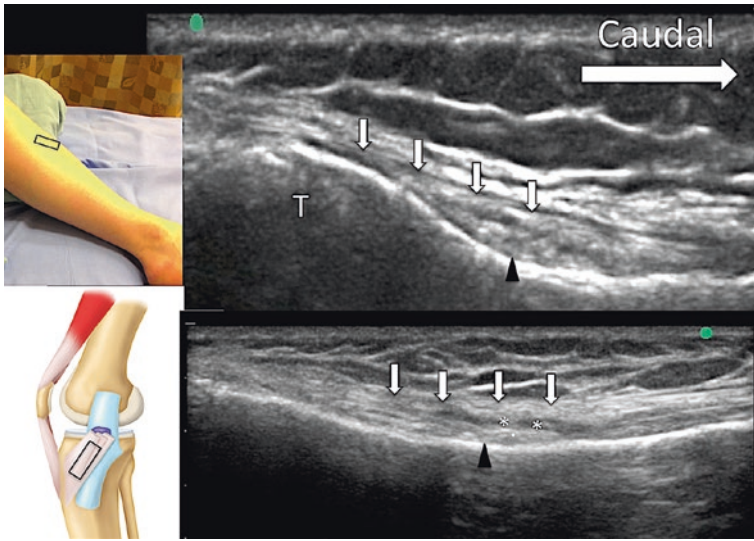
Sonographic images of pes anserinus (marked by bold arrows in upper panel) and anserine bursa (* in lower panel). Black arrow head-medial collateral ligament. (Reprinted with permission from Philip Peng Educational Series)
